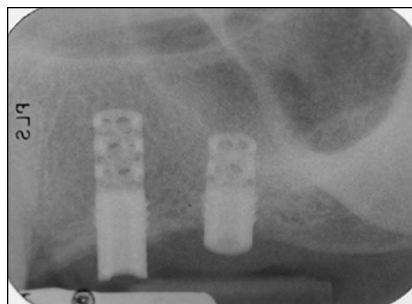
Periapical radiograph of fractured implants in #13 and 15 positions.
